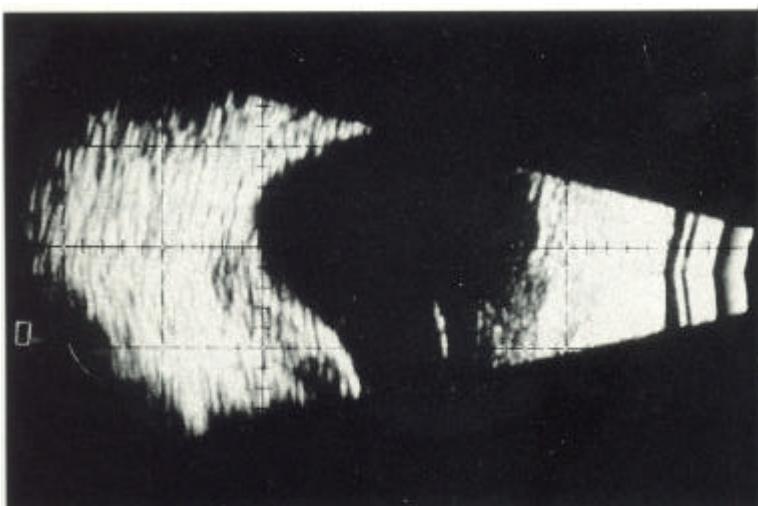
B-scan ultrasonography is the most effective way of diagnosing this condition. There is thickening of the sclera and separation of the episclera as a result of the inflammation. Exudative retinal detachment can also be detected by this method.
